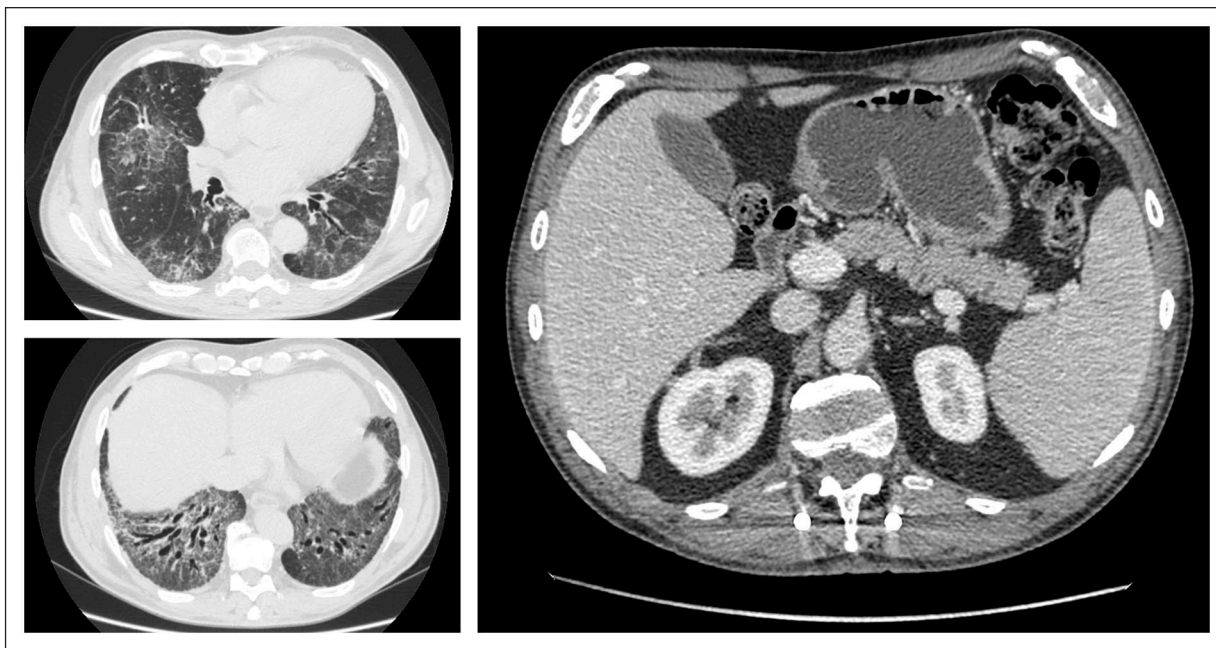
Left: HRCT images of stable ILD involvement, NSIP pattern. Right: abdomen CT showing slightly reduced splenomegaly.
